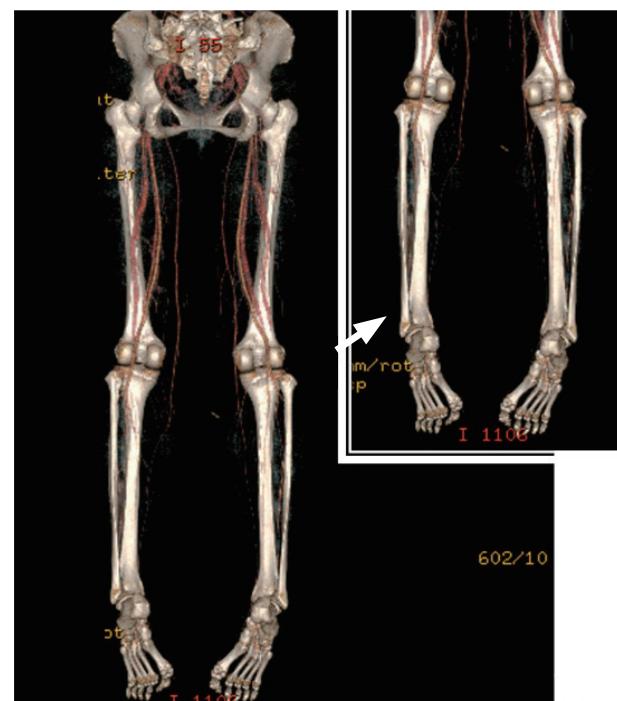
Computed tomography angiography of lower extremities. No evidence of deep vein thrombosis. But severe edema in the posterior muscular compartment of bilateral lower legs with the absence of venous drainage was detected.
